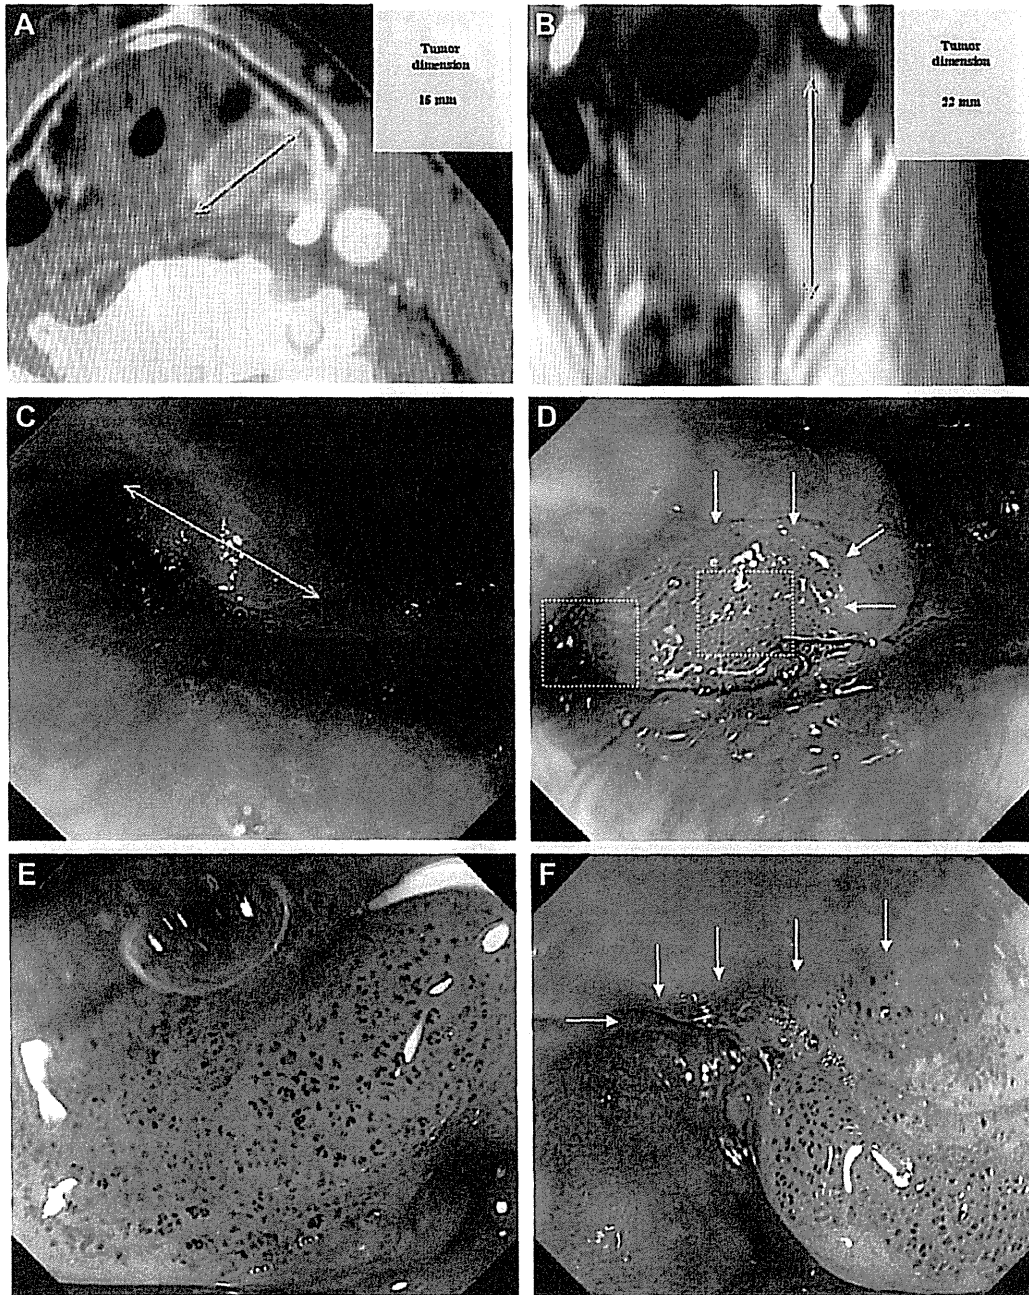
Advanced hypopharyngeal cancer arising in the left postcricoid area. The tumor was nonulcerative and situated mainly in the submucosa. Superficial cancer spread extended from the surface of the lesion to its distal border. (A) The greatest tumor dimension was 15 mm in the transverse plane on computed tomography (CT). (B) The greatest tumor dimension was 22 mm in the coronal plane on CT. (C) The greatest tumor dimension was about 25 mm on white light endoscopy. (D) Narrow band imaging showed a well-demarcated, brownish area (arrows). (E) Narrow band imaging-magnifying endoscopy revealed an irregular microvascular pattern. (F) Superficial cancer spread about 10 mm in diameter was contiguous with the anal side of the primary tumor (arrows).
